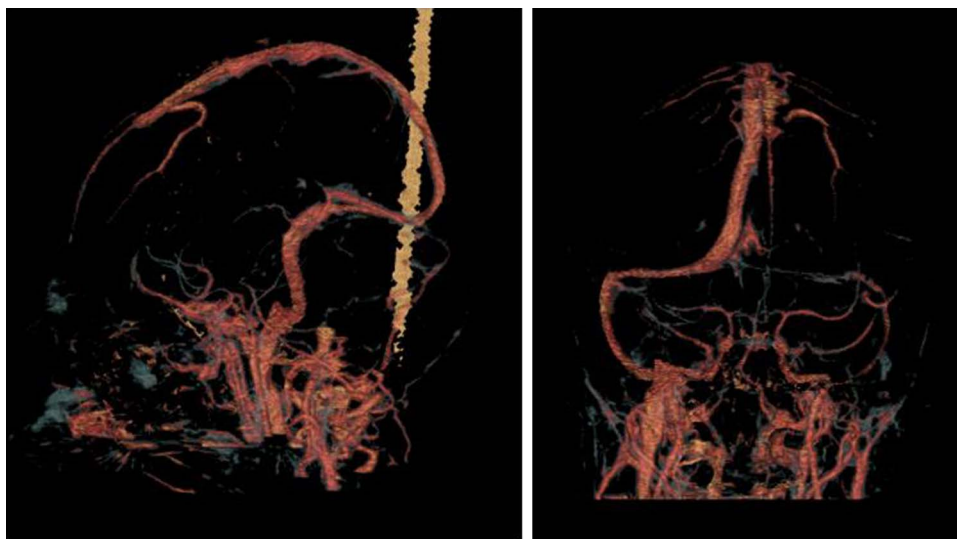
CT venogram 6 months post-treatment showing complete recanalisation of the straight sinus with antegrade flow from the deep veins, and partial recanalisation of the left transverse sinus.
